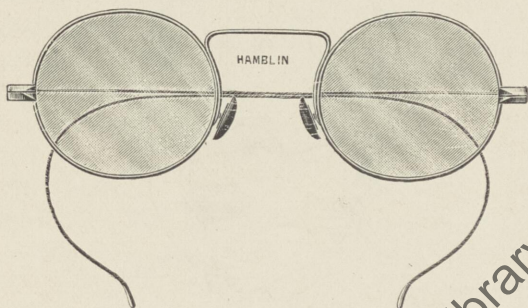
SCHOLAR'S SPECTACLES.
